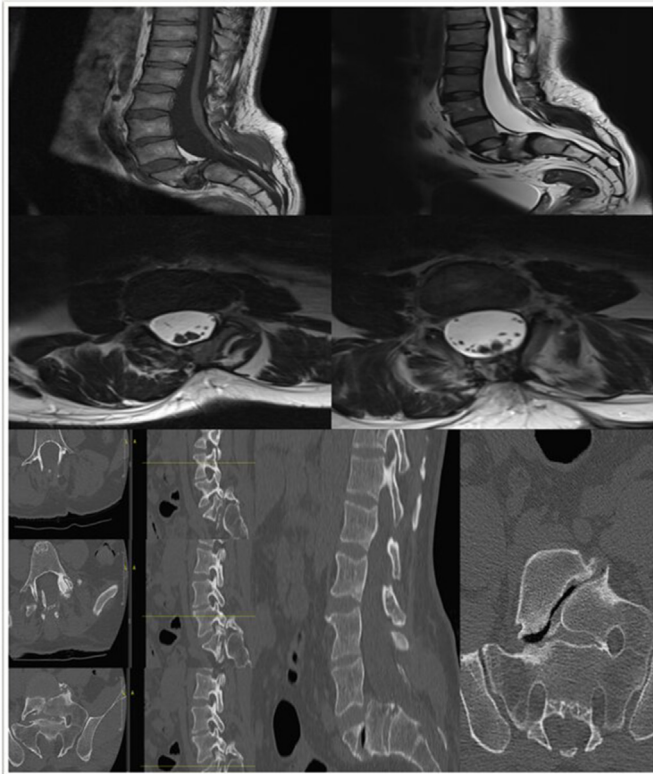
CT/MRI lumbosacral spine. Shows high-grade spondylolisthesis of L5/S1, bilateral pars interarticularis defects at L5, significant wedging of the left side of L5 vertebral body and right side of S1, low lying spinal cord terminating at S1 level (tethered spinal cord) associated with intraspinal lipoma opposite S3 and S4 levels measuring 3 cm in craniocaudal dimension, split cord malformation at L3 level with no associated bony bar, bony defect of the posterior elements of the lower lumbar and sacral region with a dorsal dermal sinus extending from the skin surface to the thecal sac at L3-4 level.
